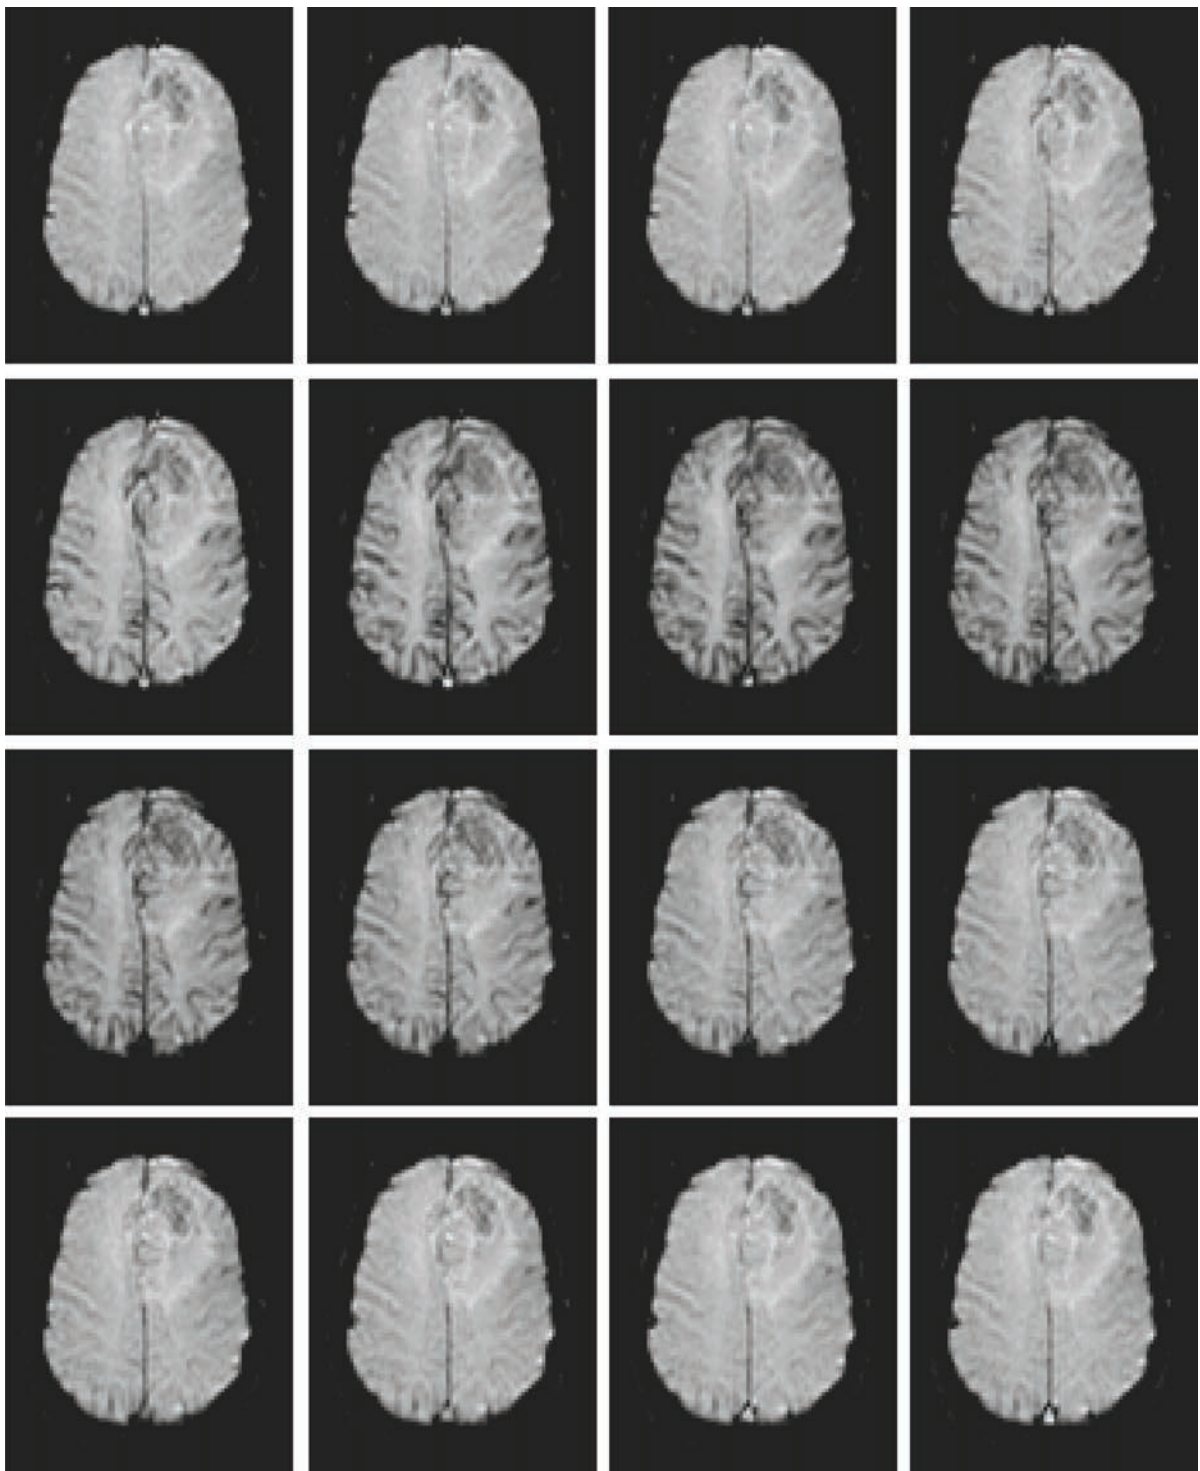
Sixteen images from a DSC-MRI examination of a low-grade glioma as the bolus of gadolinium passes through the vasculature. Time runs from left to right then down the rows, temporal resolution 1.2 s. As the bolus of gadolinium passes through the vasculature the signal intensities drop because of reductions in T_2^* .
